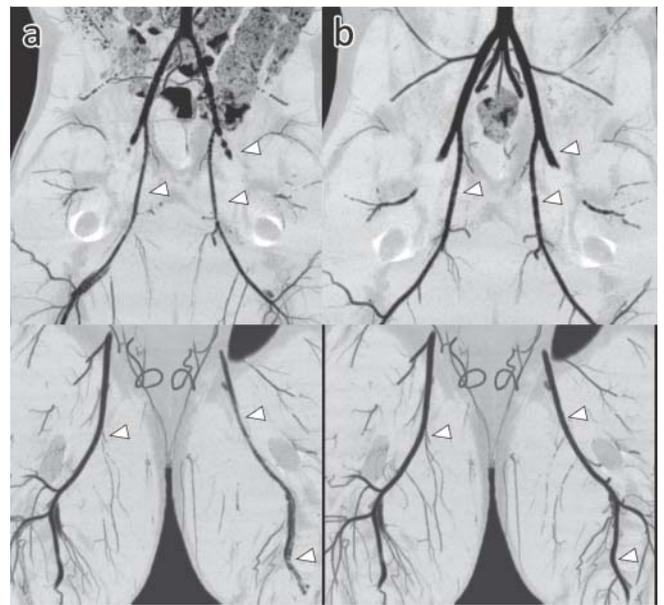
Standard (1.0, left) versus high pitch (3.0, right) CO<sub>2</sub> CT angiography. High pitch yields a more expanded depiction of the vessels as compared to the standard pitch examination (arrowheads).
